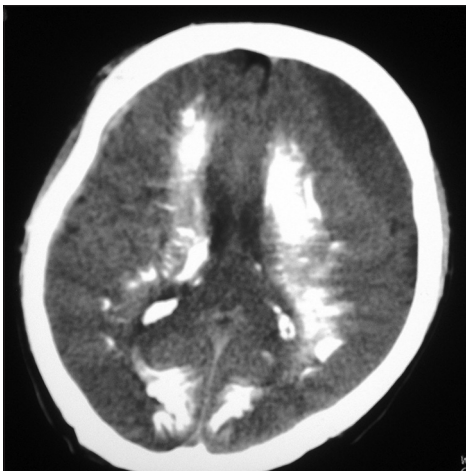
Computed Tomography of patient bilateral intracerebral calcifications and left parietal side subdural hematoma (axial)
